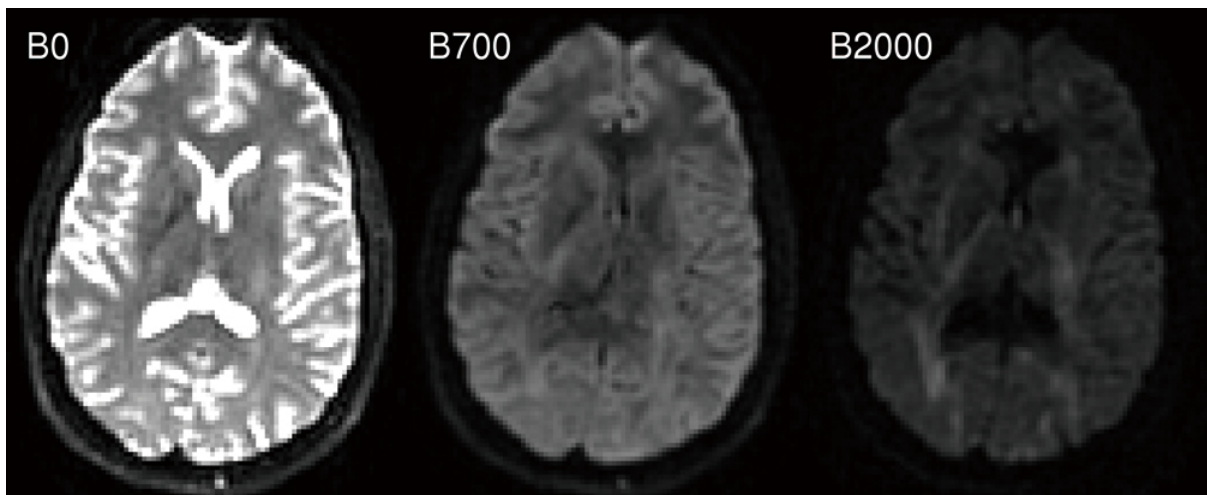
4 Different degrees of weighting in DWI (Winston et al., 2012)
